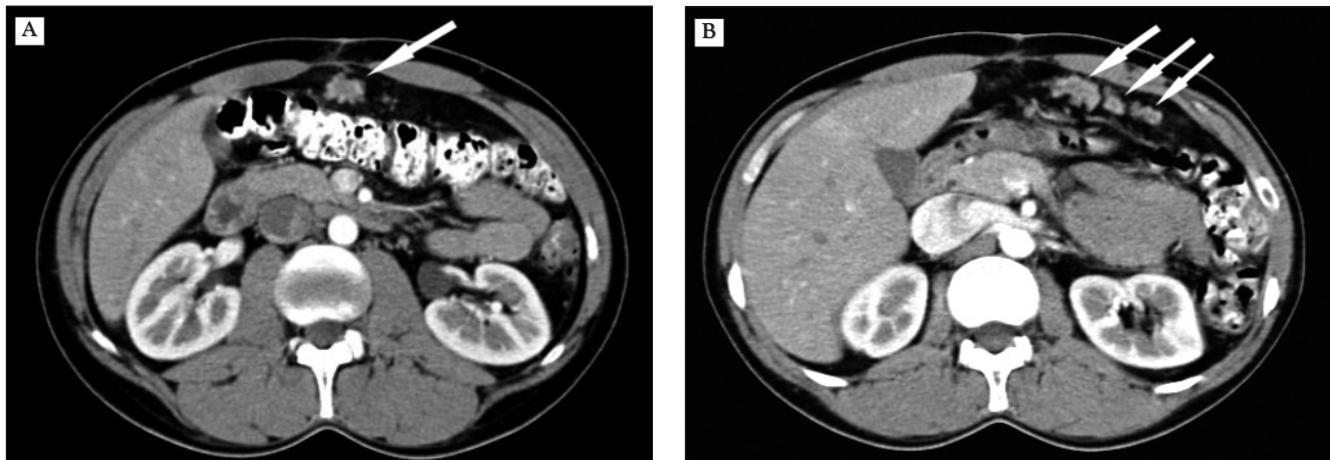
CT scan – personal collection
